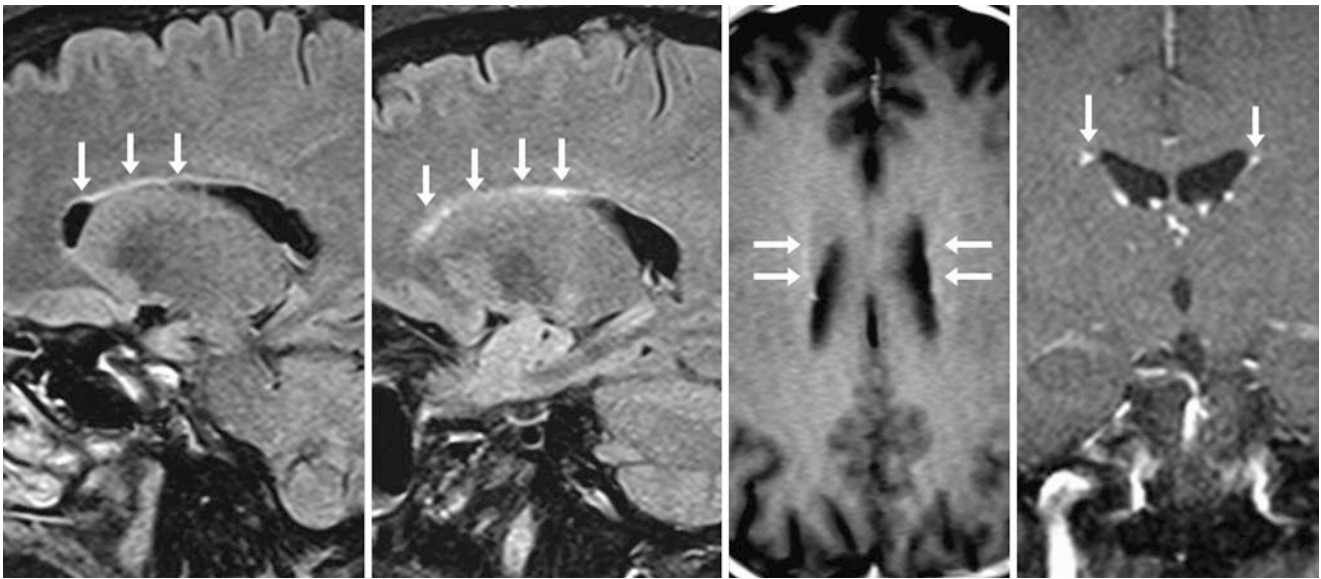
A 53 year old showed mild hyperintense signal (*arrows*) in a parallel configuration to the lateral ventricles on sagittal FLAIR images of the left (*leftmost image*) and right (*left of middle*) sides, which is immediately superior to the caudate heads (*) on axial (*right of middle*) and coronal (*rightmost image*) postcontrast T1WIs. These
